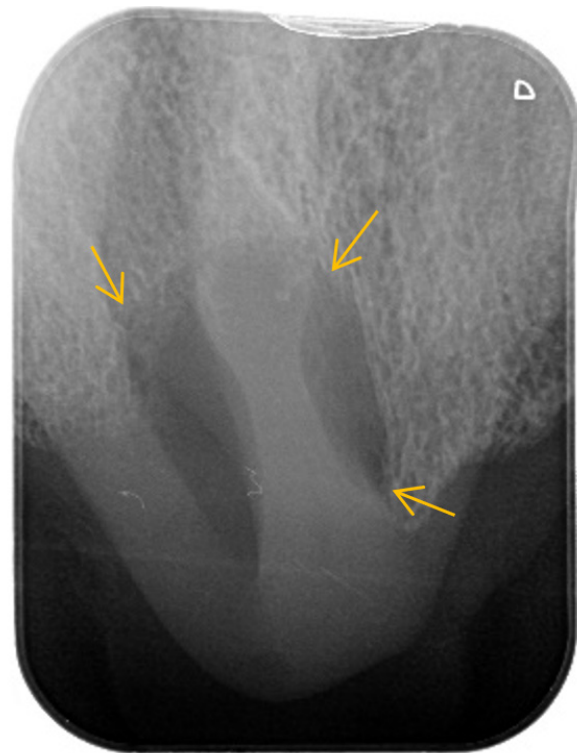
Periapical radiography of the anterior maxilla. Note the non-corticated borders of the radiolucent lesion (yellow arrows)
